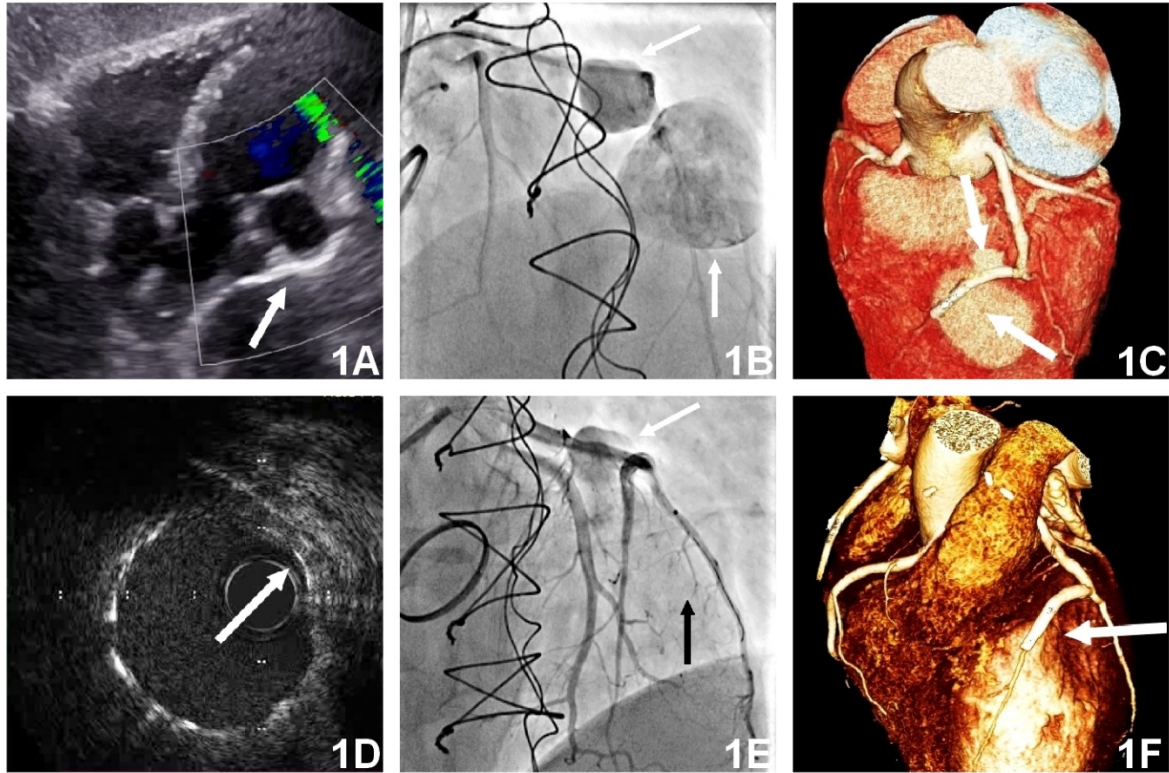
A. An additional chamber on echocardiography (white arrow). B. Aneurysms of the left anterior descending artery (LAD) on angiography (white arrows). C. Aneurysms of the LAD on computed tomography (white arrows). D. Aneurysms on intravascular ultrasound (a floating stent in the aneurysm, connection between the vessel and stent walls — white arrow). E. The LAD after the covered stent procedure (the first aneurysm with the remaining contrast material – white arrow; the second aneurysm not visible — black arrow). F. Follow-up computed tomography at 3 months after the covered stent procedure; no signs of the additional chambers (white arrow)
